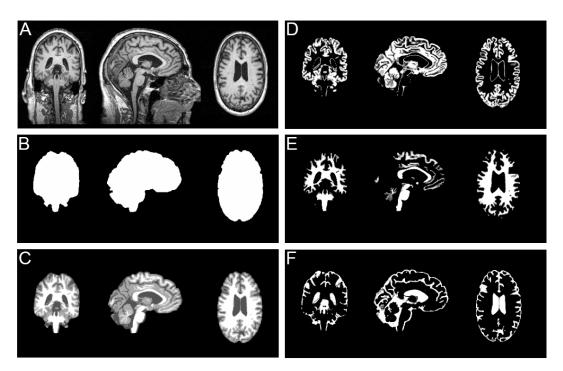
Example of output images from the Segmentation module. A is the original MRI (T1w); B is the brain mask; C is the tissue-labeled image; D, E and F are the probabilistic tissue segments.
